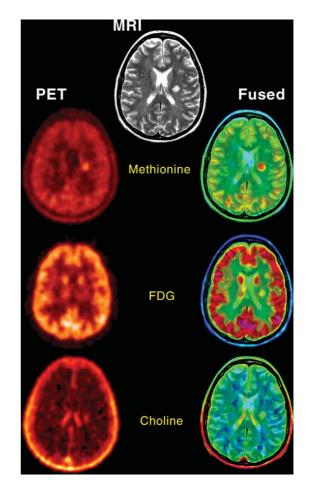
Gd-MRI and the co-registered images of PET showing a single enhancing  $1.2 \times 1.4$  cm area of hyper signal in the left corona radiata on T2-weighted images on the MRI of the brain; prominent methionine, mild glucose and choline uptake in the lesion.
